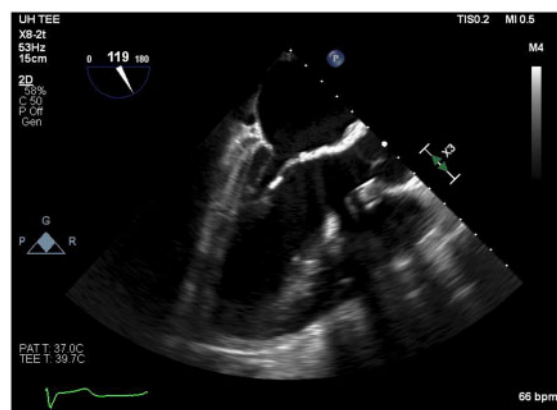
Echocardiogram demonstrating diffuse, radiation-induced calcification extending from the interannular fibrosa to the mitral valve leaflets.
